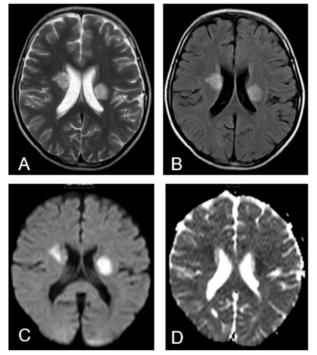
MRI-T2 AXIAL (A) and FLAIR axial (B) images showing hyperintensity with restricted diffusion in DWI(C) and ADC (D) map over bilateral basal gangliasuggestive of acute infarct
